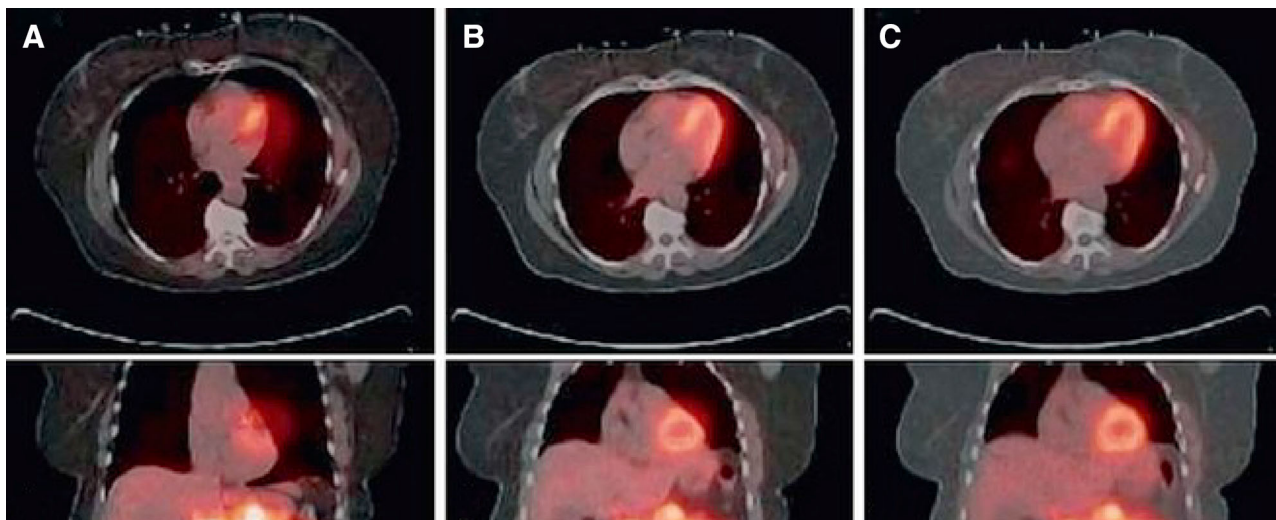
An example of 3 different CT protocols for AC. (A) Breath-hold CT at inspiration. This is not suitable for AC. (B) Free-breathing low-pitch CT. (C) Free-breathing time averaged cine CT. In B and C, note the superior alignment between the PET and CT images compared with the breath-hold CT. (Reprinted with permission from Votaw and Nye⁵).
